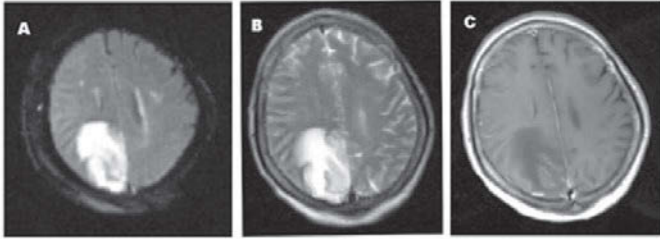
MR imaging performed on day 15 shows extension of the pathologic changes: heterogeneous increased signal on DWI (A) refers mainly to T2 shine-through effect, T2-WI (B). Contrast-enhanced T1 weighted images demonstrates meningeal and subtle intraparenchymal enhancing (c). On the basis of the MR imaging findings, examination of CSF a diagnosis of herpes encephalitis was considered.
